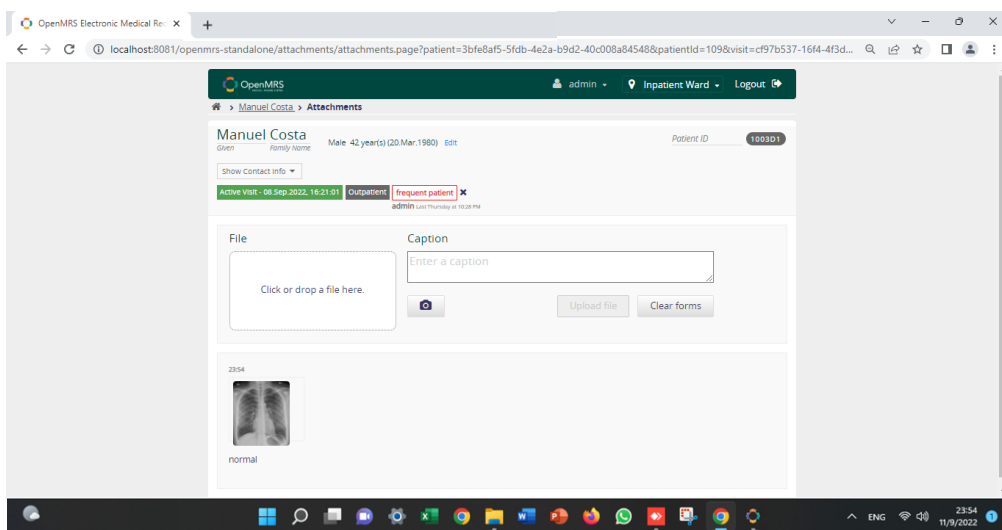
Attachment of an x-ray to a patient's health record file.
